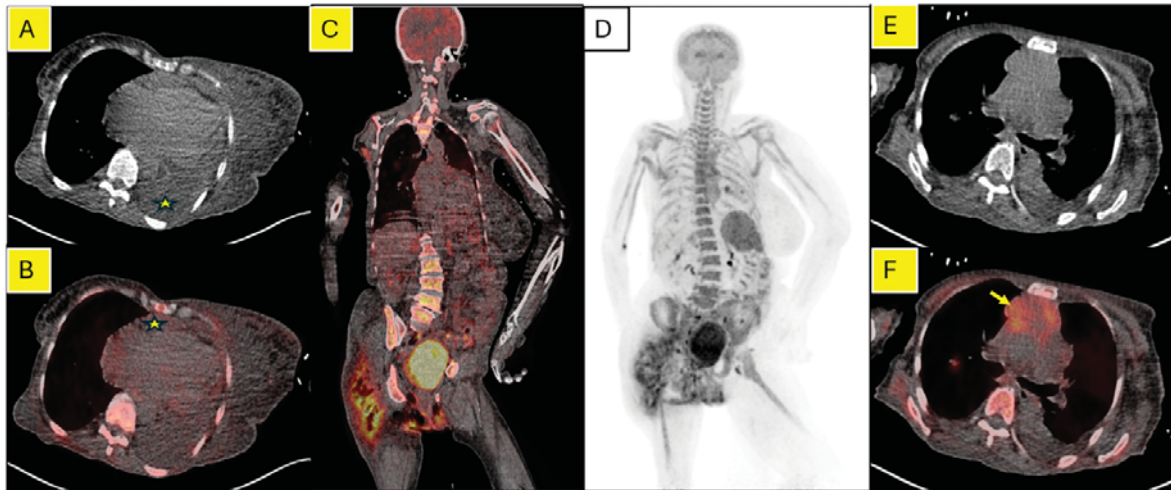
(A-F): FDG PET/CT study. A (CT axial) and B (fused axial) showing pericardial and left pleural effusion (yellow asterisk); C (fused coronal) image showing hypermetabolic emphysematous lesion in right gluteal and vulva; D (maximum intensity image MIP) showing generalized enhanced uptake in marrow and spleen (indicators of septicemia); E (CT axial) and F (fused axial) showing biopsy proven Squamous Cell Ca. of anterior mediastinal mass (yellow arrow).
